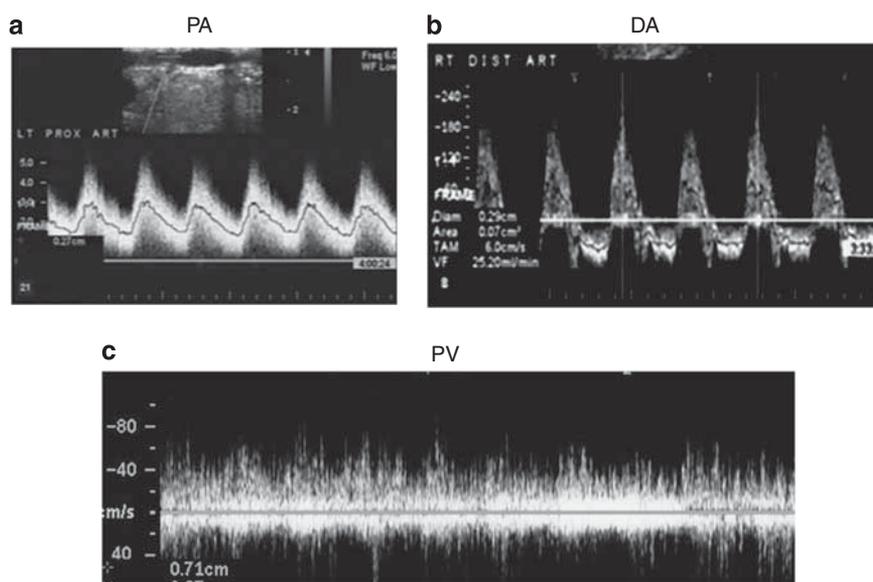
Representative Doppler ultrasound measurements. Representative Doppler ultrasound recordings at the PA (a), DA (b), and PV locations (c). Note the expected flow reversal during diastole within the distal artery. PA, DA, and PV denote proximal artery, distal artery, and proximal vein locations, respectively.
